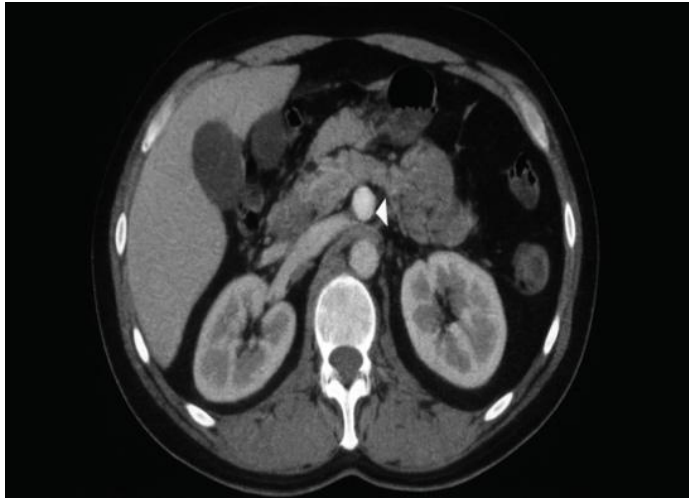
Contrast-enhanced abdominal CT scan (axial view) showing compression of the left renal vein between the aorta and the superior mesenteric artery, consistent with anterior Nutcracker syndrome. Both kidneys are well opacified without evidence of hydronephrosis.
